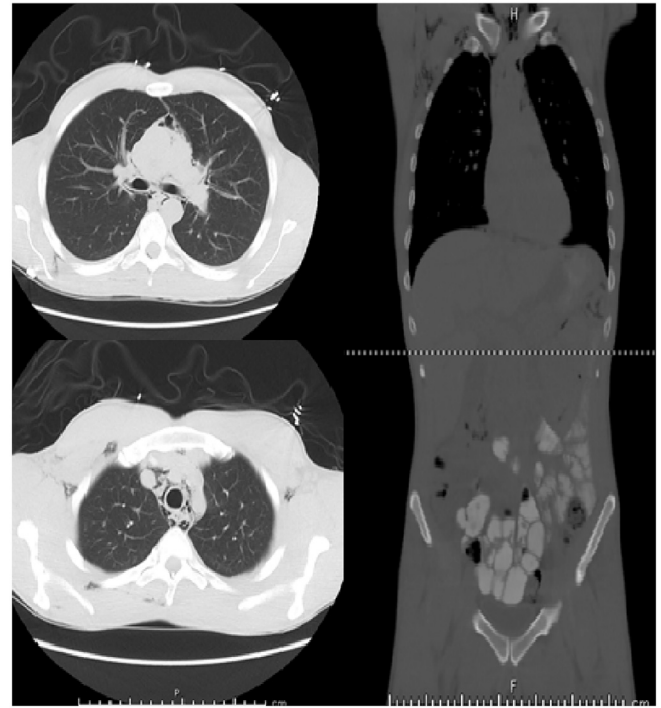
CT images showing diffuse pneumomediastinum with associated soft tissue gas in the lower neck and upper chest bilaterally.
